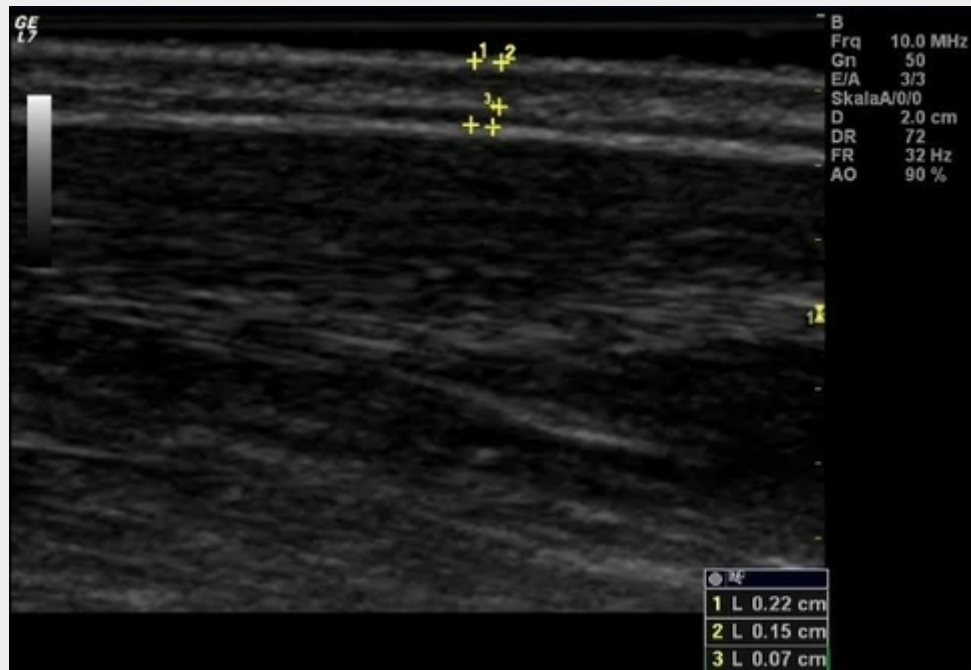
Ultrasound image from the skin. The skin and its two layers are labeled with yellow crosses.
